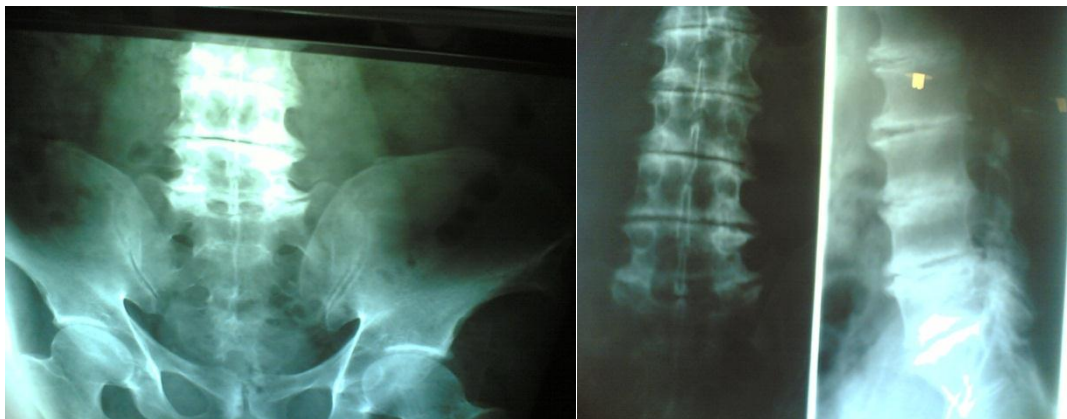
X-rays of patients showed normal SI joint, calcified disks, OA hips
